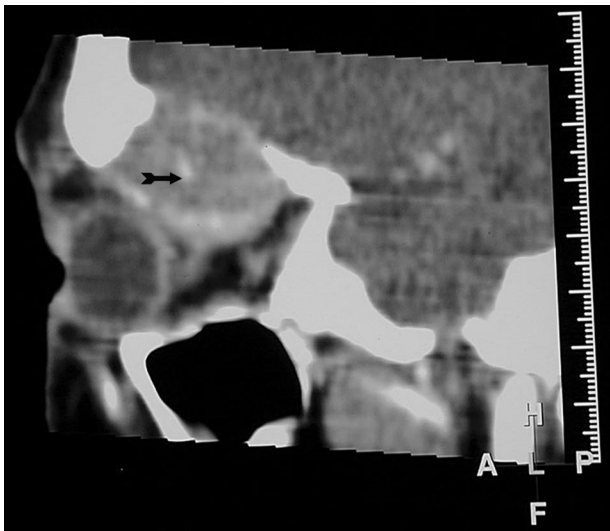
Coronal CT shows an enhancing soft tissue mass arising in the orbital roof, which has displaced the globe downward. It is associated with bony erosion of the orbital roof superiorly and the medial wall of the orbit (black arrow points to the defect in the upper table of the frontal bone; gray arrow points to the defect in the medial wall).
